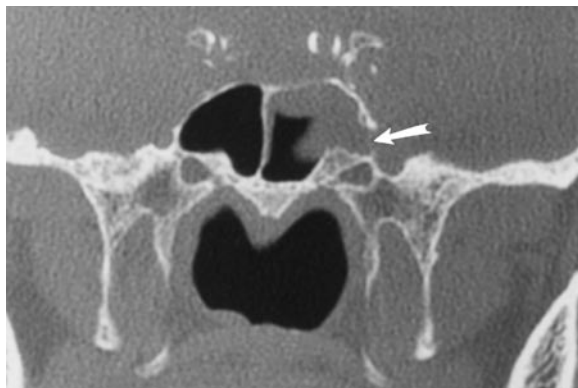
Coronal CT through sphenoid sinus demonstrates herniation of an arachnoid granulation (arrow) responsible for cerebrospinal fluid rhinorrhea
